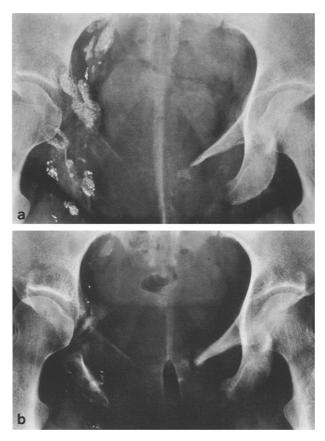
Pedal lymphangiography in 1987 before radiotherapy (a) and radiographs one year later (b)
